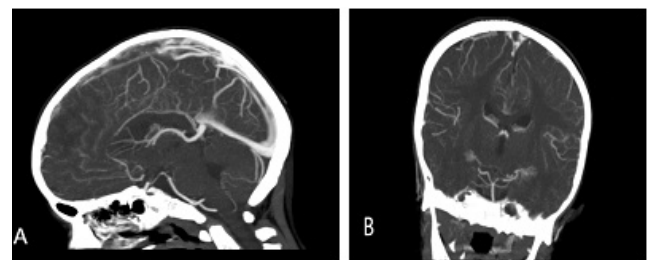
Cerebral computed tomography angiogram; (A) Sagittal view; filling defect in superior sagittal sinus (white arrow) (B) Coronal view; empty delta signs (white arrow) in confluence site; suggestive of thrombosis.
